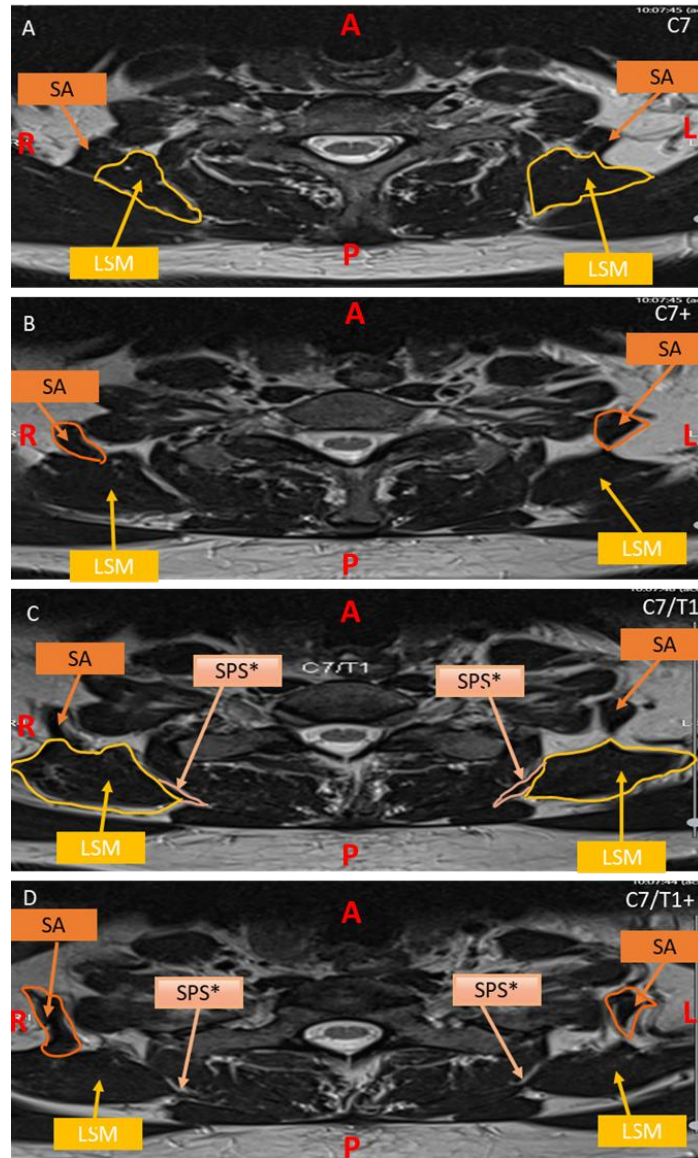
The axial cervical MRI scans with serratus posterior superior and serratus anterior attachments of levator scapulae muscle (A to D = superior to inferior). The MRI scans were obtained from a 54-year-old male patient (p# 19) with bilateral accessory attachments to the serratus posterior superior. Key: C- cervical vertebrae, LSM- levator scapulae muscle, SA- serratus anterior SA*- attachment to the serratus anterior, SPS*- attachment to the serratus posterior superior, SPS- serratus posterior superior, T- thoracic vertebrae. Orientation in red: A- anterior, L- left, P- posterior, R- right.
